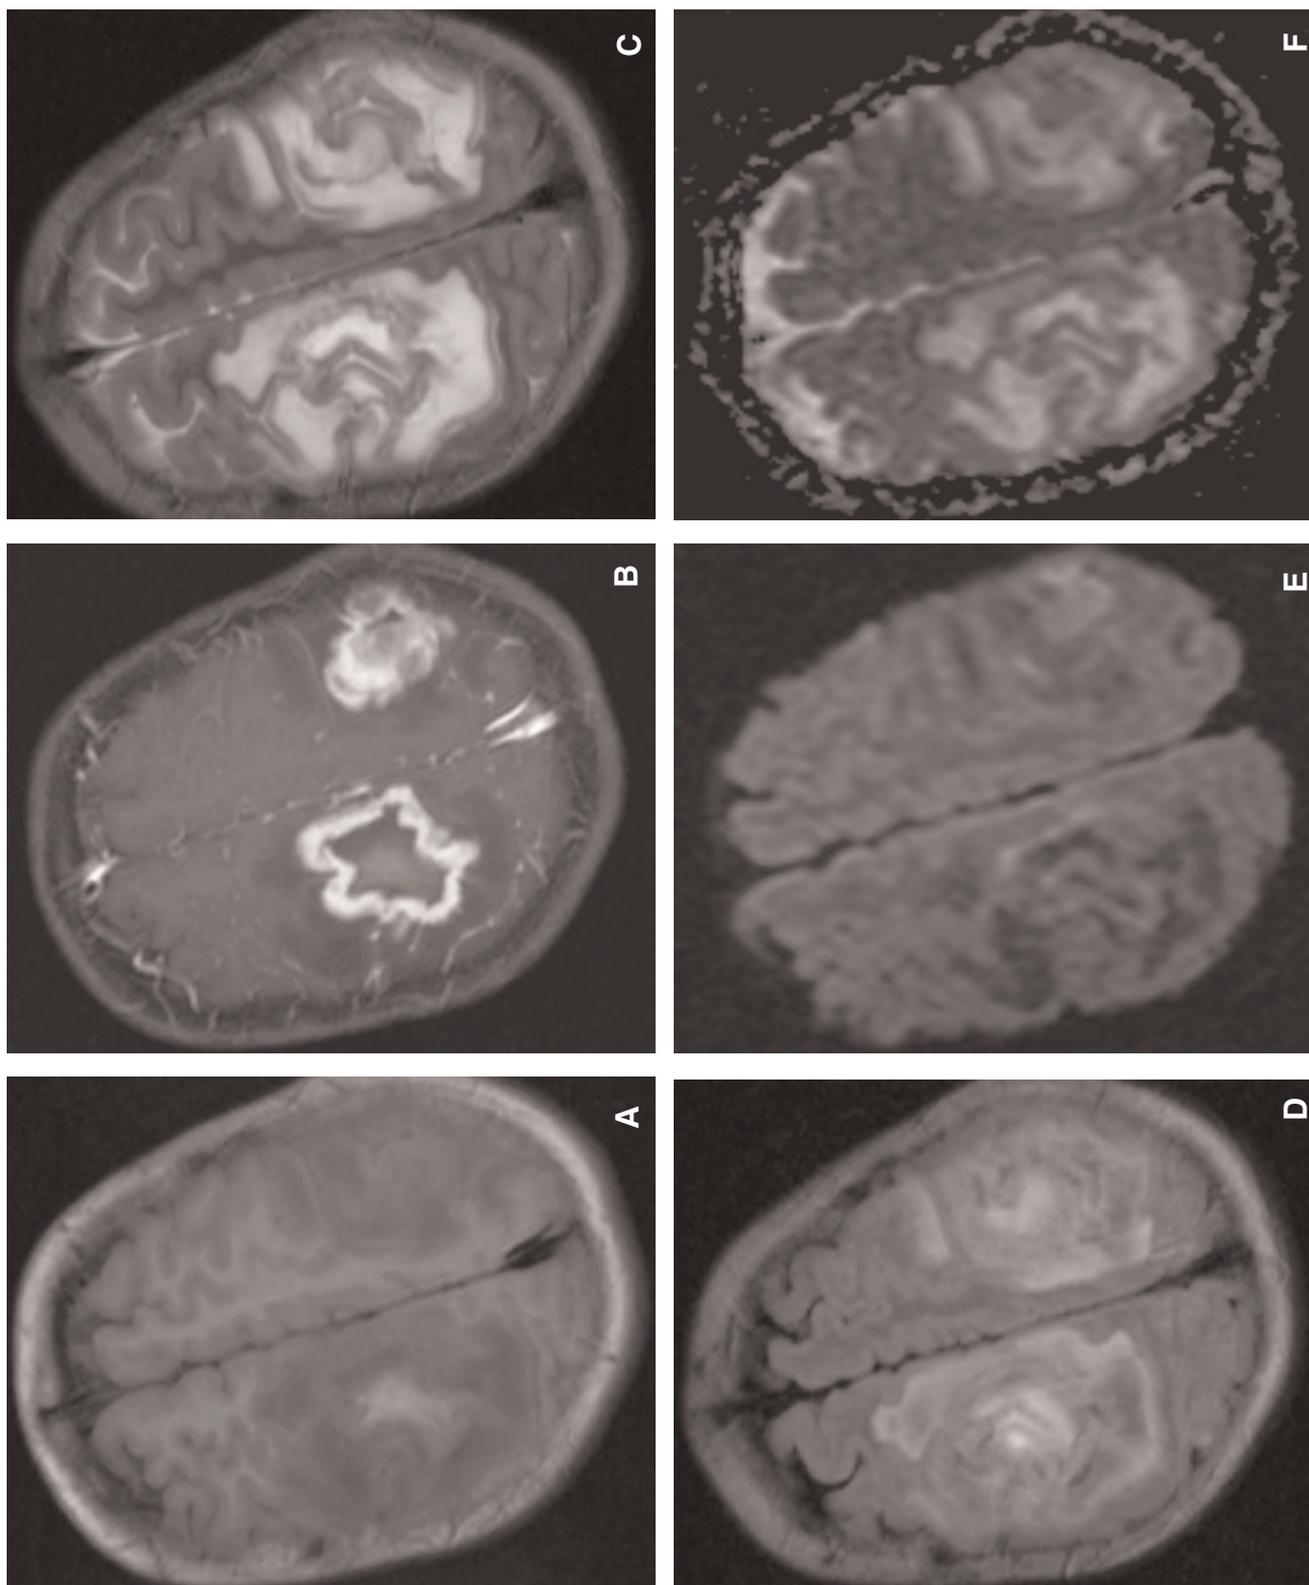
Magnetic resonance imaging at the same level 17 days after symptom onset shows marked interval enlargement of the right and left frontal lesions. Axial T1 weighted images without (A) and with (B) gadolinium now show significant ring-enhancement of the lesions. T2W (C) and FLAIR (D) images show pronounced edema of the surrounding parenchyma. Restricted diffusion is no longer apparent (E) and (F).
